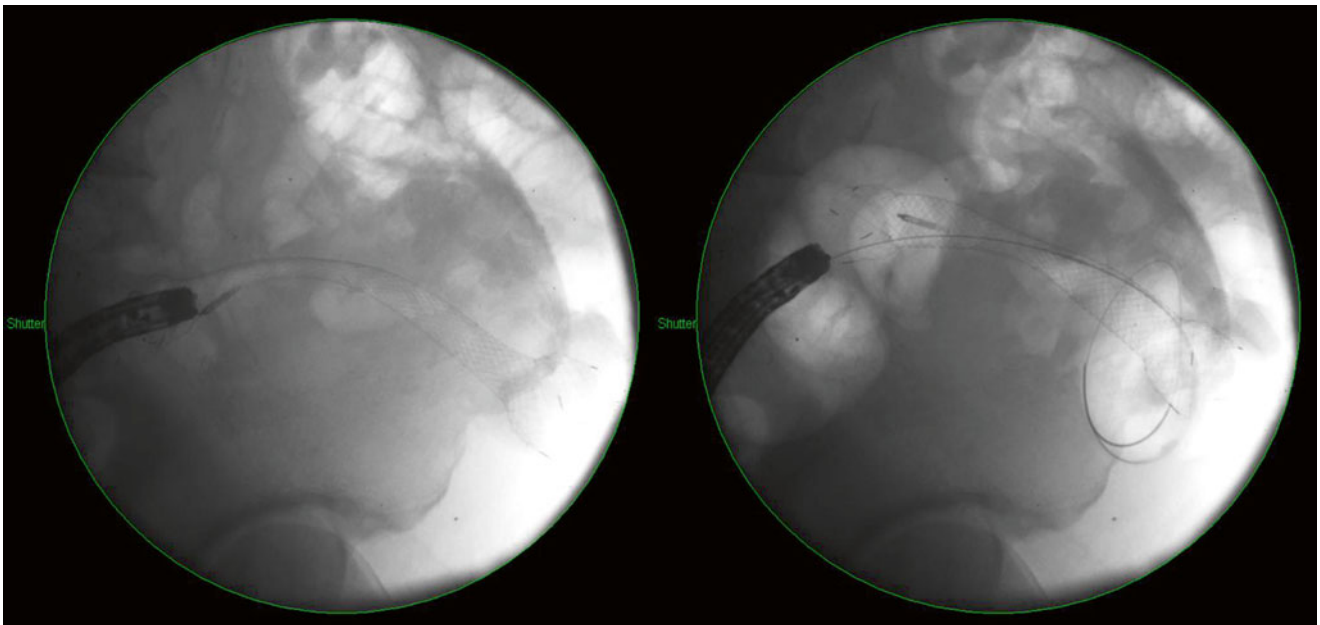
CT—stent deployed in malignant bowel obstruction
